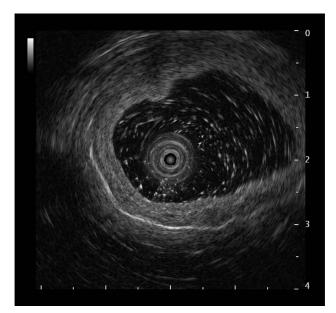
Endoscopic ultrasound images showing that the true and blind portions of the duodenum share a muscular layer.
